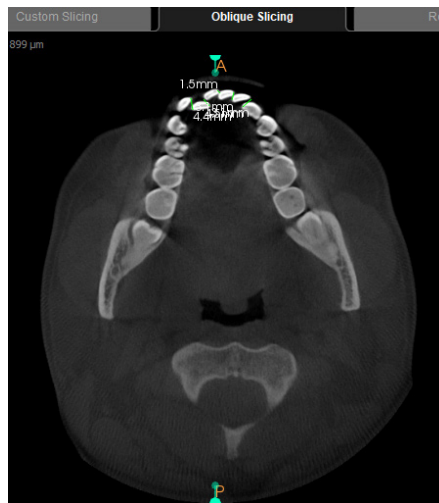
Measurements of Little's Irregularity Index using cone beam computed tomography axial view.
